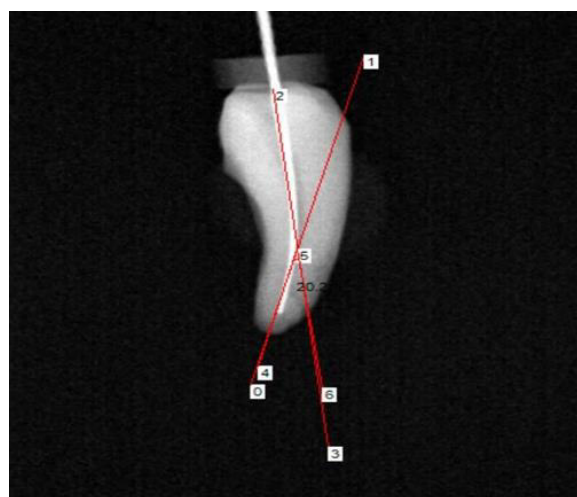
Radiograph after instrumentation measuring angle of canal
